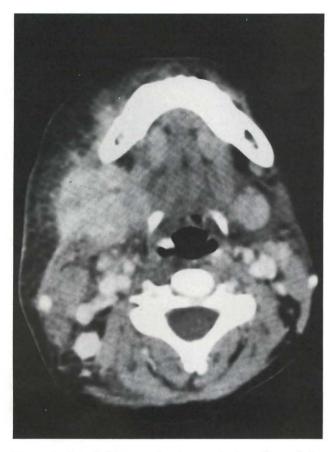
Initial CT scan showing marked swelling of the right submandibular space. Note the patency of the airway.
